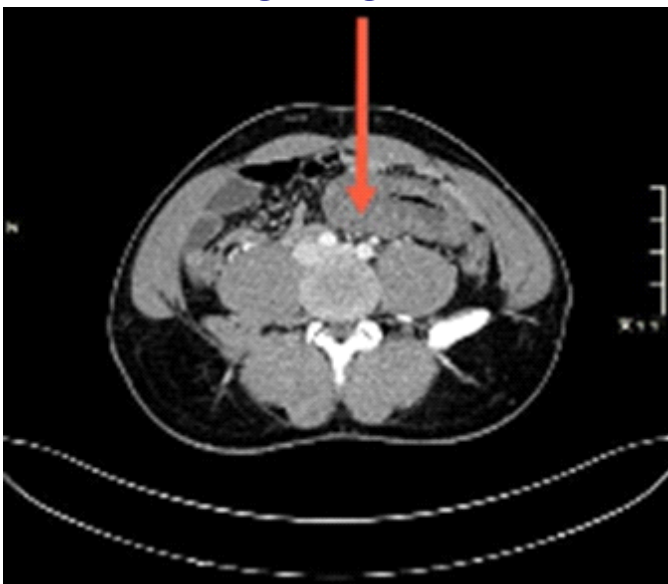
CT image of abdomen showing bowel wall thickening indicating ischemia
